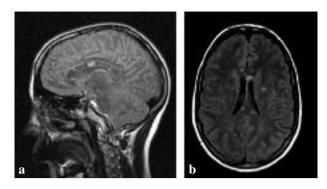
a) Sagital FLAIR MR image showing hyperintense lesions in the corpus callosum; b) Axial FLAIR MR image showing multiple hyperintense lesions in the periventricular white matter and a hyperintense lesion in the corpus callosum.
